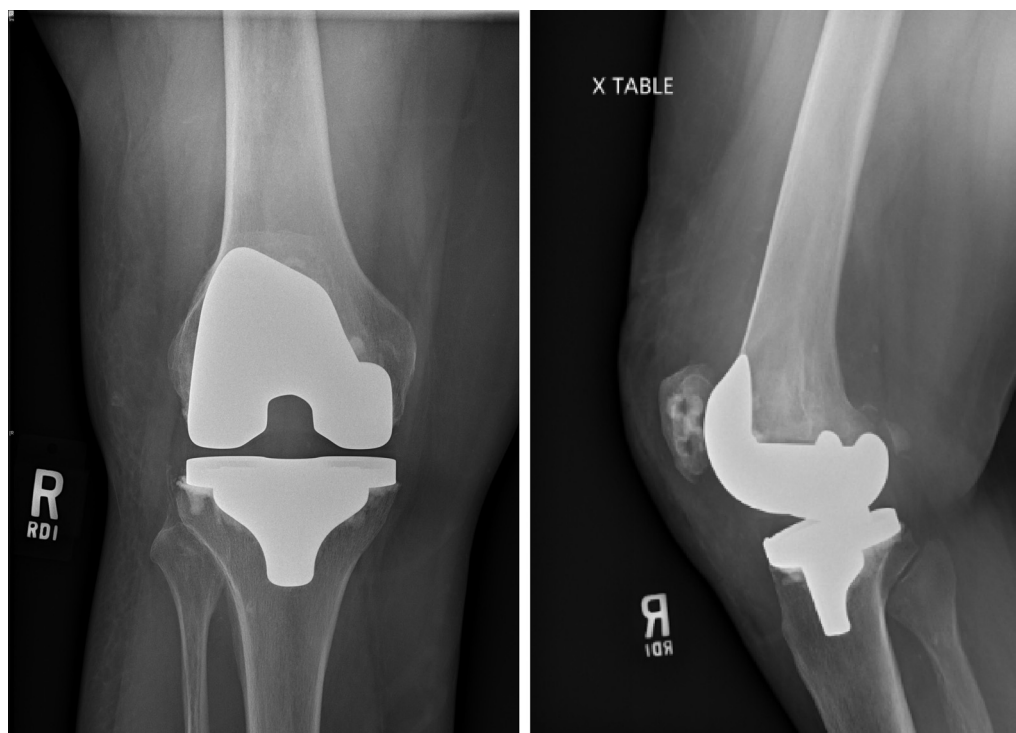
Postoperative radiographs after the index operation for the total knee replacement.
